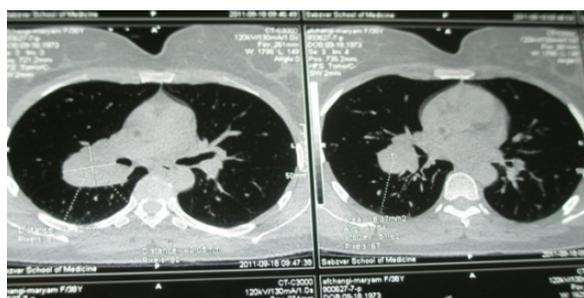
Thoracic computed tomography scan showed a 4×4 cm mass lesion with regular contours located in the right middle zone.
